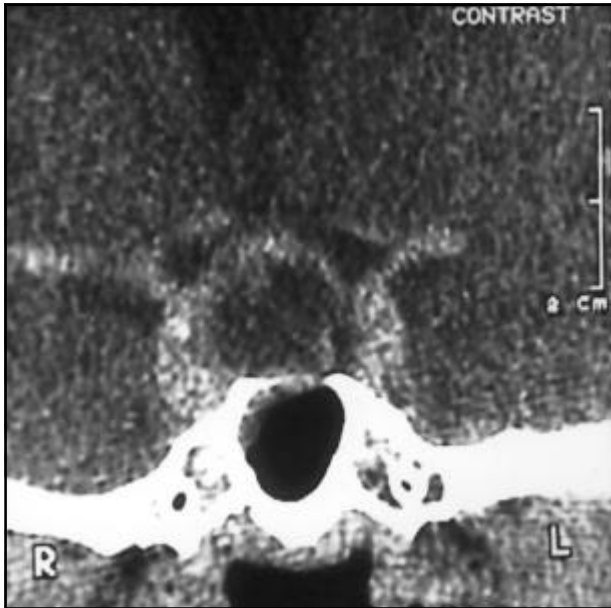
CT scan 2mm thick section after intravenous contrast injection. Space-occupying lesion in the sella turcica with a suprasellar extension and destruction of the sellar floor. Note the presence of hypodensity at the center of lesion with a contrast-enhanced outline, filling up the sphenoidal sinus.
